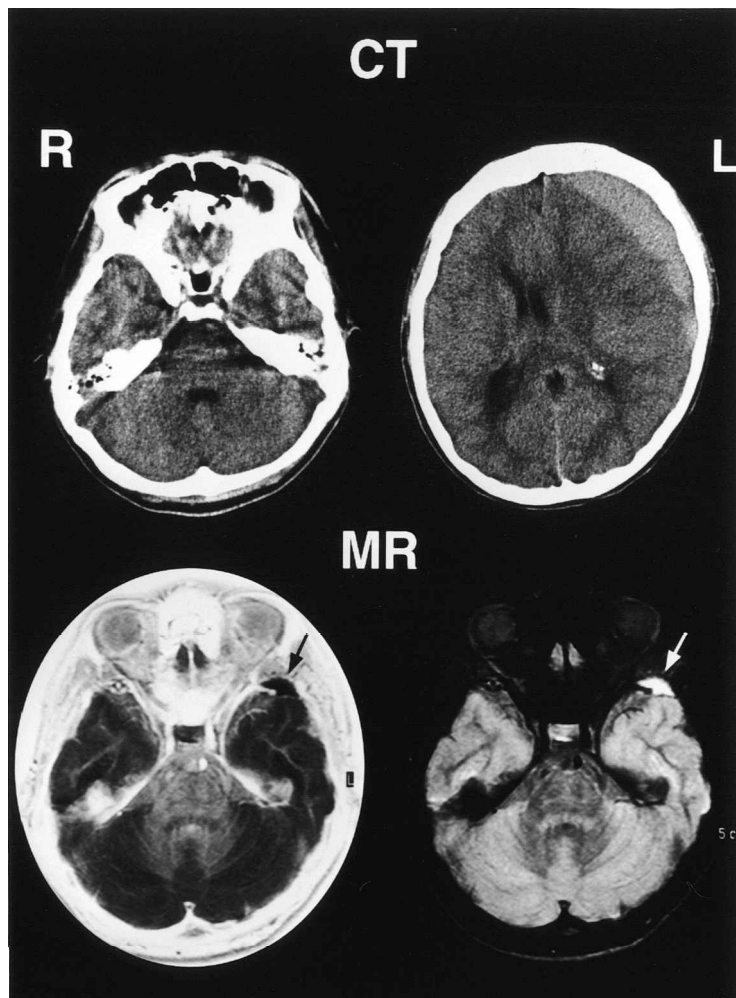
Patient 11. Upper: CT scans showing a high density subdural hematoma in the left frontal region, and a small bony indentation in the tip of the left middle fossa. Lower: Postoperative MR images revealing the presence of a small arachnoid cyst in the tip of the left middle fossa.
